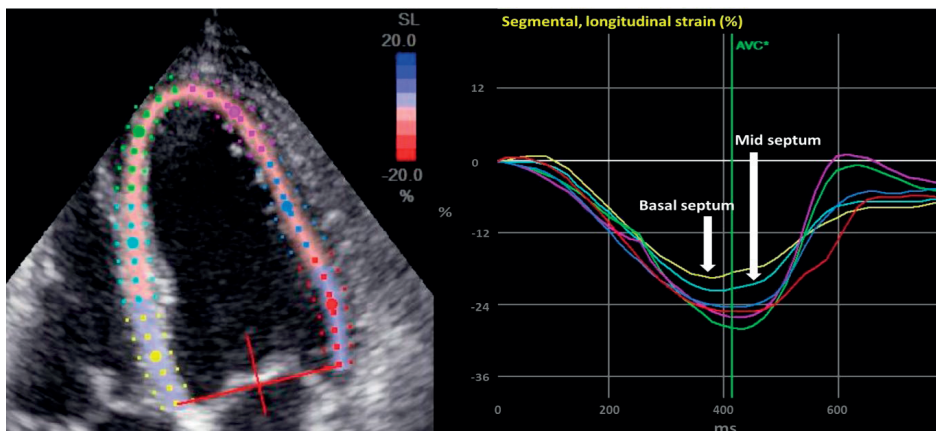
Impaired septal strain in a patient with lamin A/C mutation. Longitudinal strain is assessed with 2-dimensional speckle tracking echocardiography in the apical 4-chamber view. Different myocardial segments are indicated by different colours. White arrows identify impaired strain curves from the inferoseptal basal and midventricular myocardial segments. AVC: aortic valve closure.
